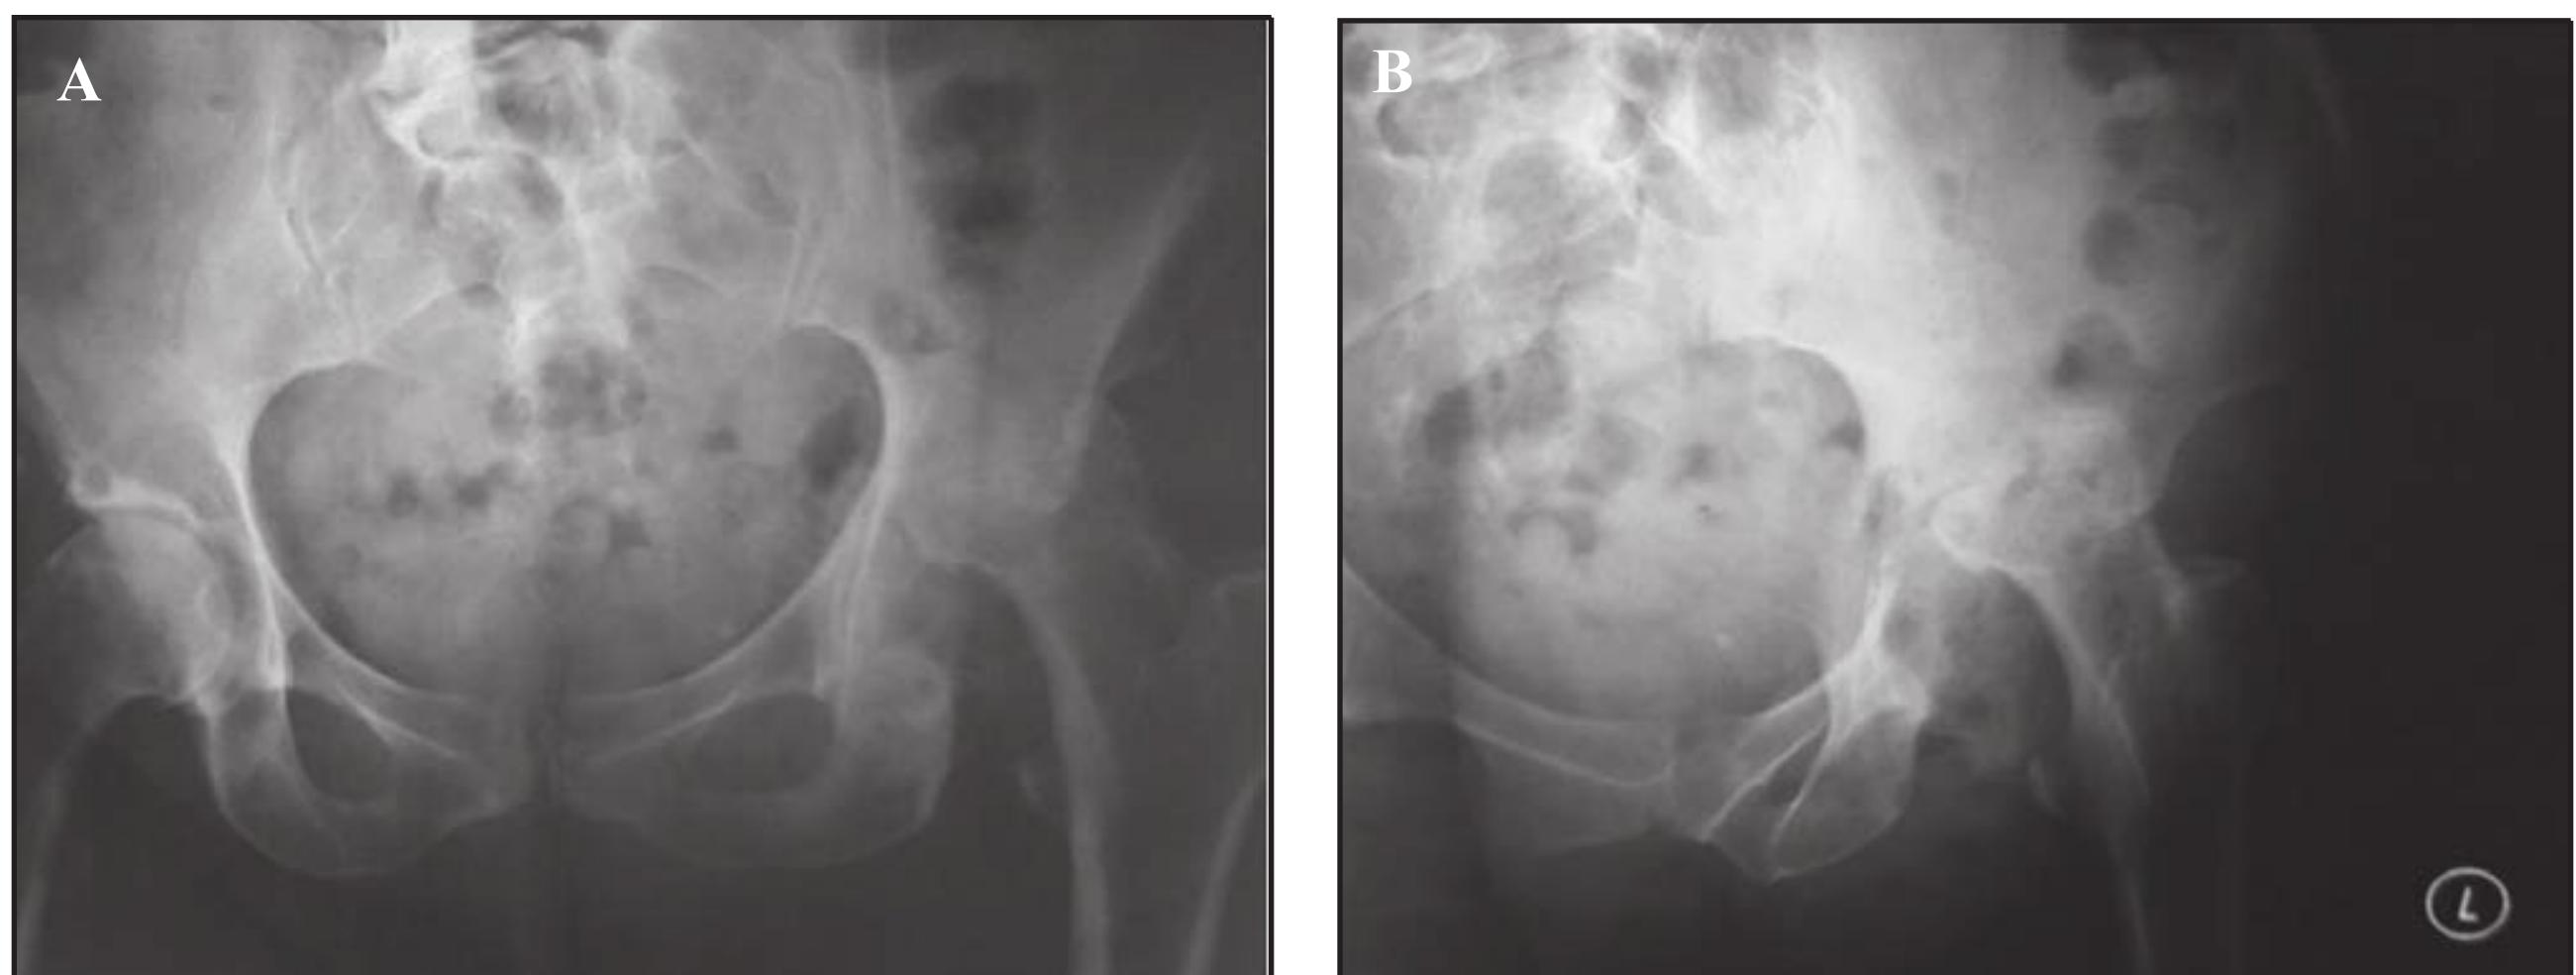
(A) AP pelvis radiograph of a 46-year-old female with a history of severe left hip pain. Note the superior migration of the femoral head and resultant leg length discrepancy. (B) AP hip radiograph of the same patient demonstrating severe acetabular bone loss in this native hip.
